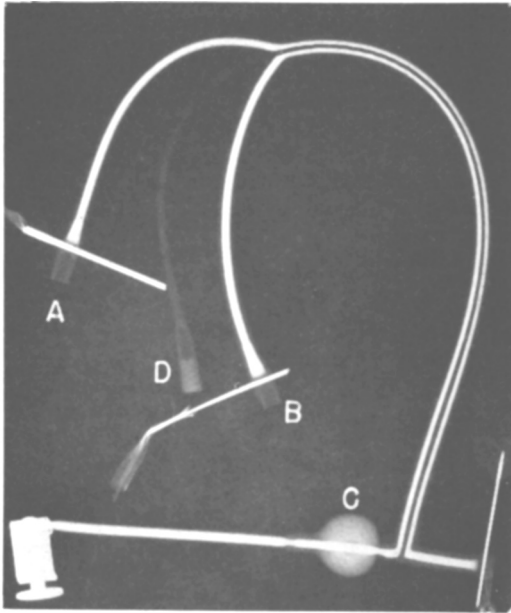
Special T-tube for total bile collection: X-ray study of Urokon-filled tube to demonstrate its internal structure. Proximal tube (A), distal tube (B), balloon (C), and self-sealing tube to fill balloon (D).
